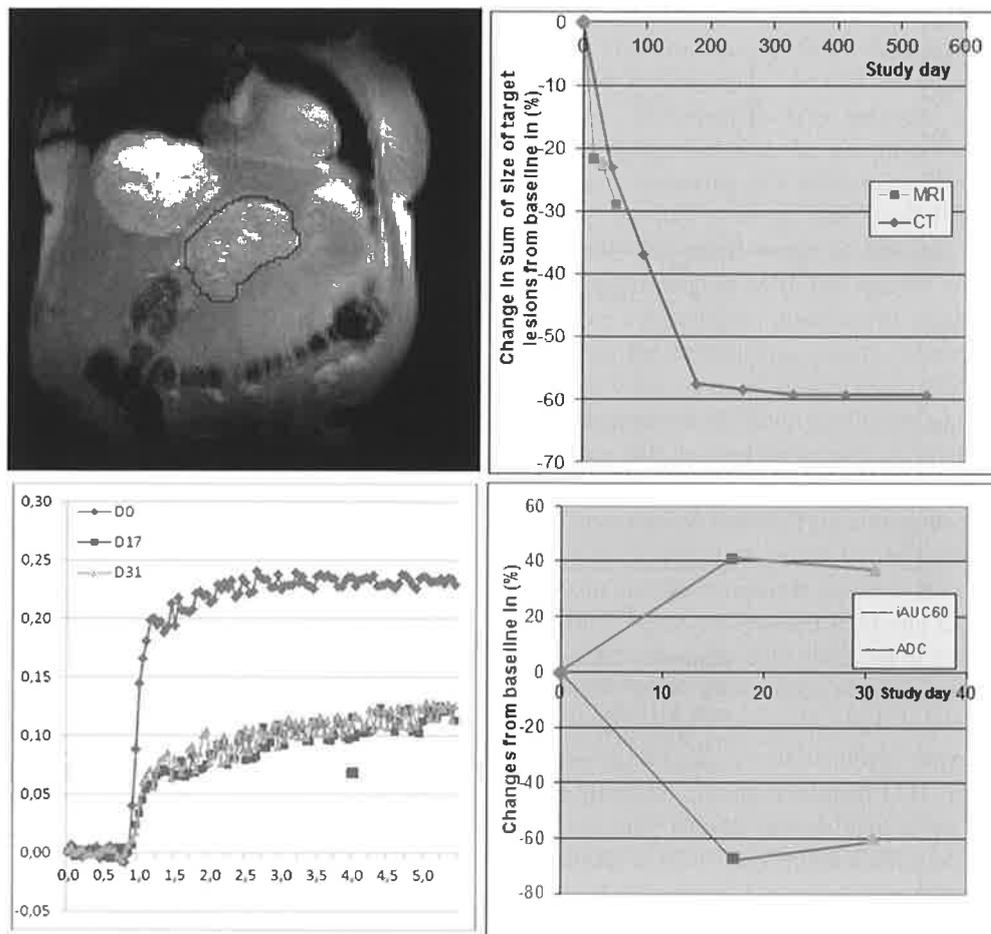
Single case example: Patient 0406. MRI with drawn region of interest of target lesion in the liver. Below are the contrast agent concentration time curves of the three examinations. The plots on the right show a strong decrease of the perfusion dominated parameter iAUC60, an increase in ADC (bottom) accompanied with a tumor size (top) reduction over the study time course. Due to patient-related reasons, functional MRI of day 52 could not be acquired.
